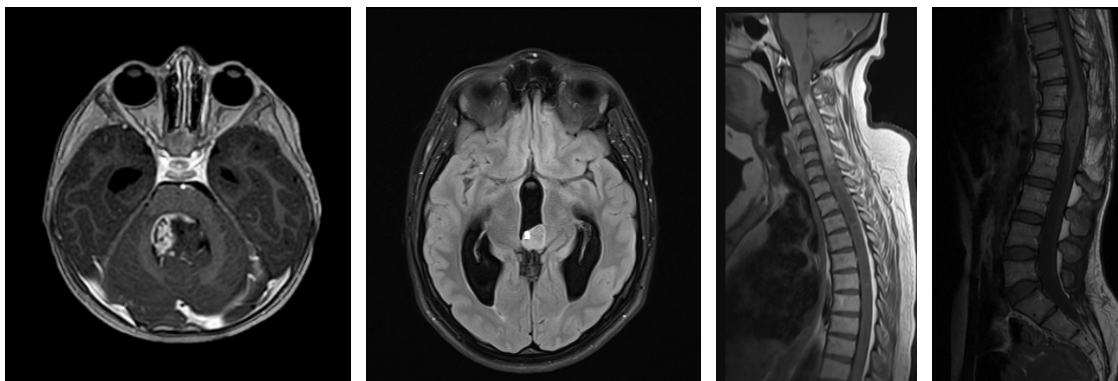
MRI scans of ependymomas are shown. The left (35) scan shows a posterior fossa EP, the middle (36) scan shows a supratentorial EP, and the two scans on the right (37, 38) show spinal EPs.
